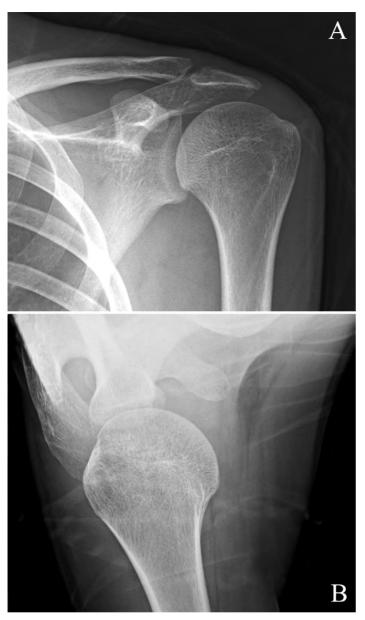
Plain radiographs six months after hardware removal demonstrating bony union.
